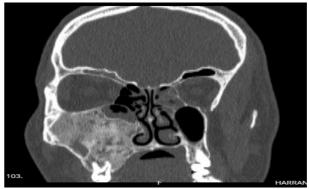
Coronal section computed tomography image of the lesion located in the posterior region of the maxilla.
